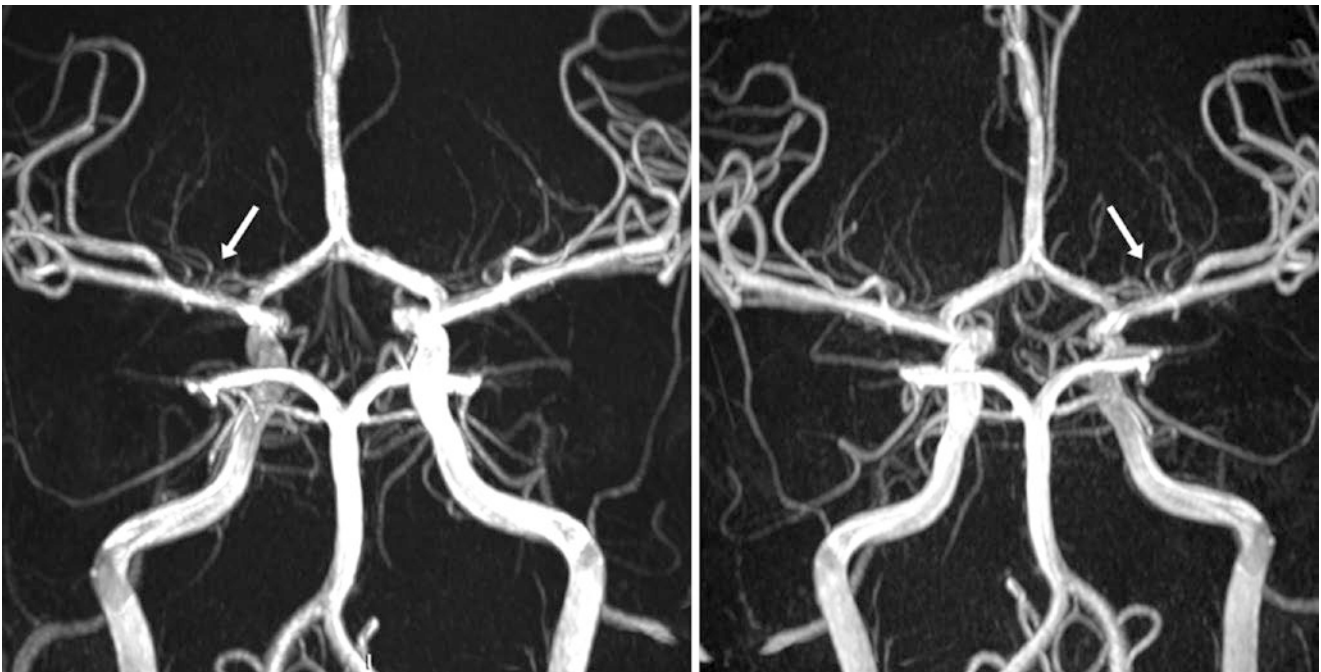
18-year-old with multiple lenticulostriate branches arising from both MCAs on 3 T high-resolution 3DTOF MRA AP views (*arrows*). These branches were not visualized at all on a 64-slice CTA (*not shown*)
